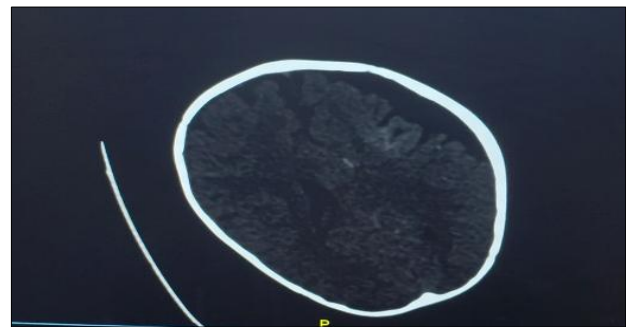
CT brain showing tram-track cortical calcifications.
